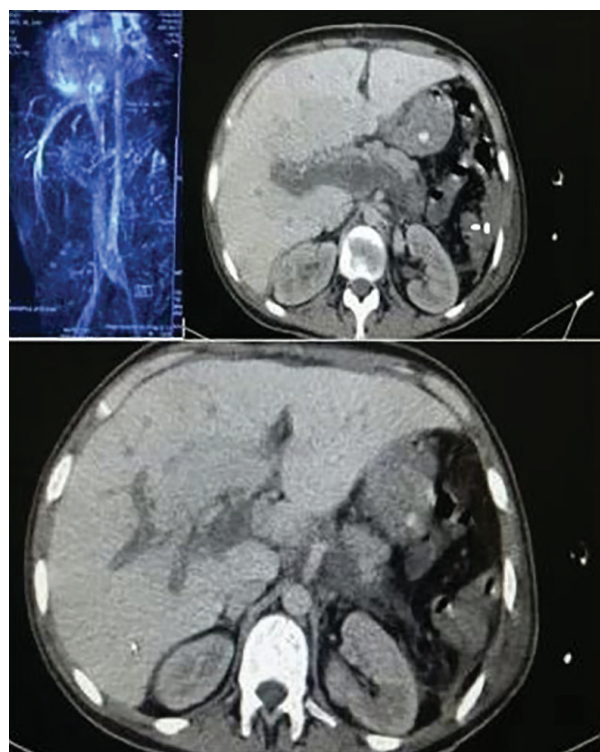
MRV images shows evidence of lack of flow in portal venous system. Abdominal CT-scan shows extensive thromboses in portal, mesenteric and splenic veins with cavernous transformation.
